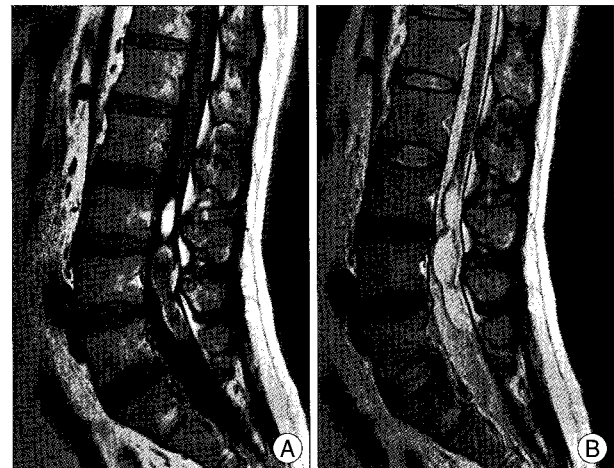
Magnetic resonance imaging on admission. T1-weighted (A) and T2-weighted (B) sagittal images reveal a sausage-like abnormal signal lesion in the conus medullaris area from the L2 to L4 level.
